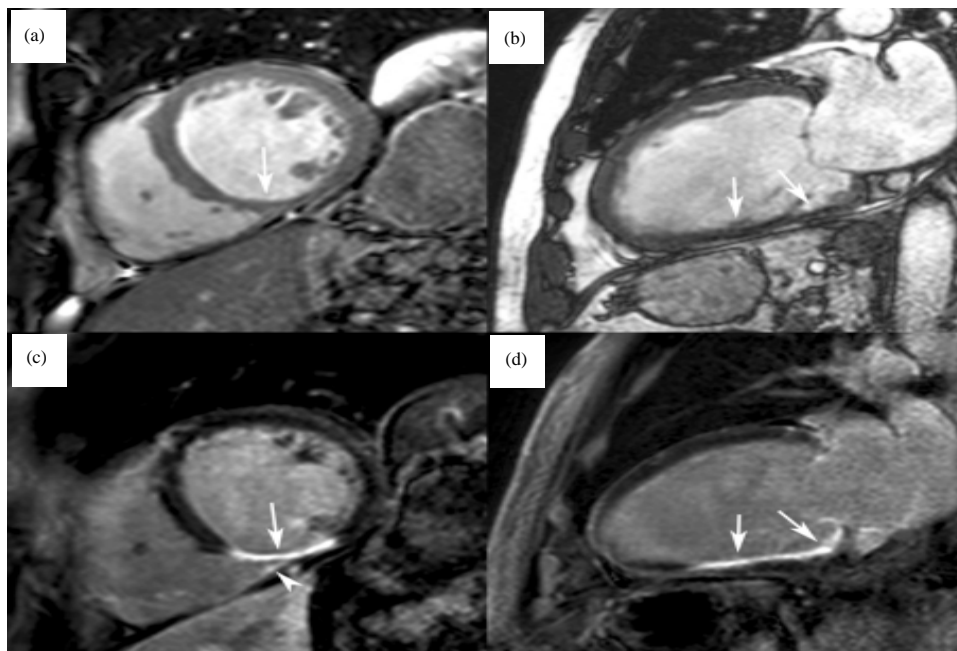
(a-d): A case diagnosed with dilated cardiomyopathy, (a) Still midventricular short-axis and (b) Vertical long-axis images of cine MRI show a remodeled, dilated LV and inferior wall thinning (arrows). Late Ce-MRI in the same imaging planes show transmural enhancement of the base and (c and d) Mid inferior wall and of the mid infero-medial RV suggests an old inferior MI with RV involvement (arrow head)<sup>19</sup>
